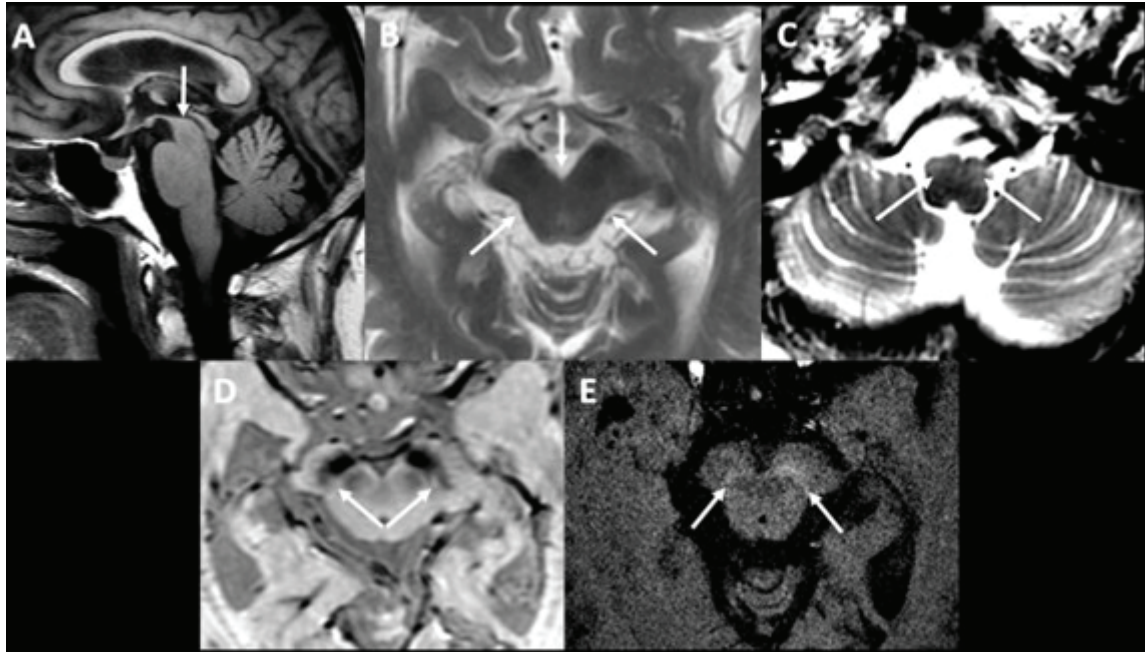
3.0 Tesla magnetic resonance imaging shows volumetric reduction of the midbrain in the sagittal T1 sequences (A), with rectification of the upper contour of the tegment (arrow) and axial T2 (B) showing prominence of the interpeduncular cistern and greater concavity of the tegment (morning glory sign – arrows) described in progressive supranuclear palsy (PSP). The T2 axial sequence of the medulla oblongata (C) shows hypersignal and hypertrophy of bilateral inferior olivary nuclei (arrows), which can be associated to progressive ataxia and palatal tremor (PAPT). Axial thin slices of the midbrain in SWI (D) and T1 (E) sequences with reduction of nigrosome1 and neuromelanin in the substantia nigra (arrows), respectively, mainly on the right, a structural biomarker of transaxonal degeneration of the striatonigral dopaminergic pathway, not specific for this entity, which can be found in other parkinsonian syndromes, such as Parkinson's disease.
